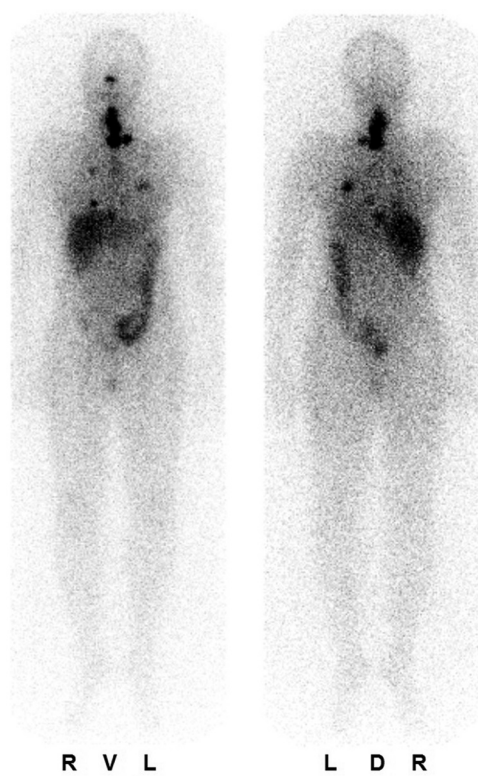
Whole-body scintigraphy of the patient acquired after ablative radioiodine therapy with ventral (left) and dorsal (right) images. Aside from the thyroid remnant, multiple cervical lymph node and pulmonary metastases can be seen. D, dorsal; L, left; R, right; V, ventral.
